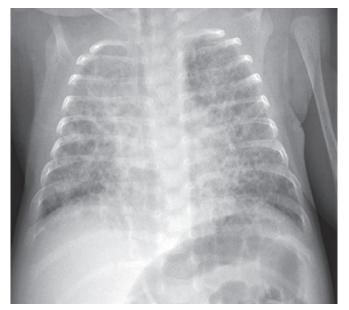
Chest X-ray of case 3 showing bilateral granular opacities with cystic changes
